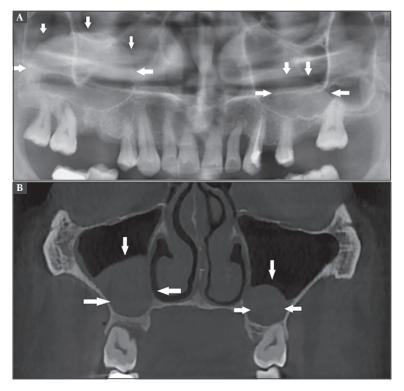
Cropped panoramic radiography (A) and coronal CBCT image (B) show bilateral retention cysts(arrow).
